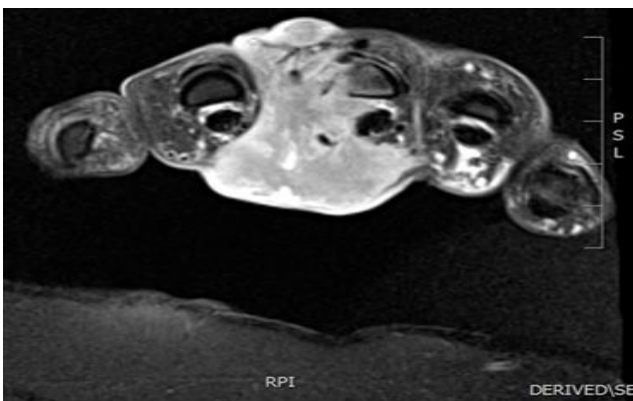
Initial transverse plane MRI of left hand, of malignancy invading the 2nd and 3rd metacarpals.
